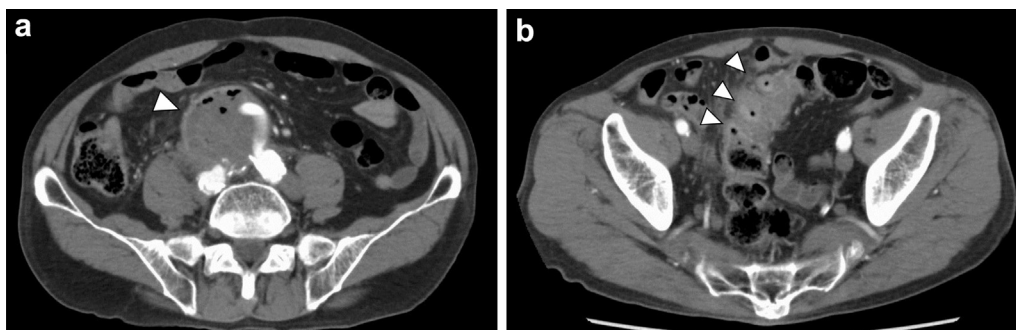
Preoperative computed tomography showing (a) an enlarged sac around the occluded right leg of the prosthetic graft with gas bubbles surrounding the graft; (b) three high-density spots between the enlarged sac and sigmoid colon.
